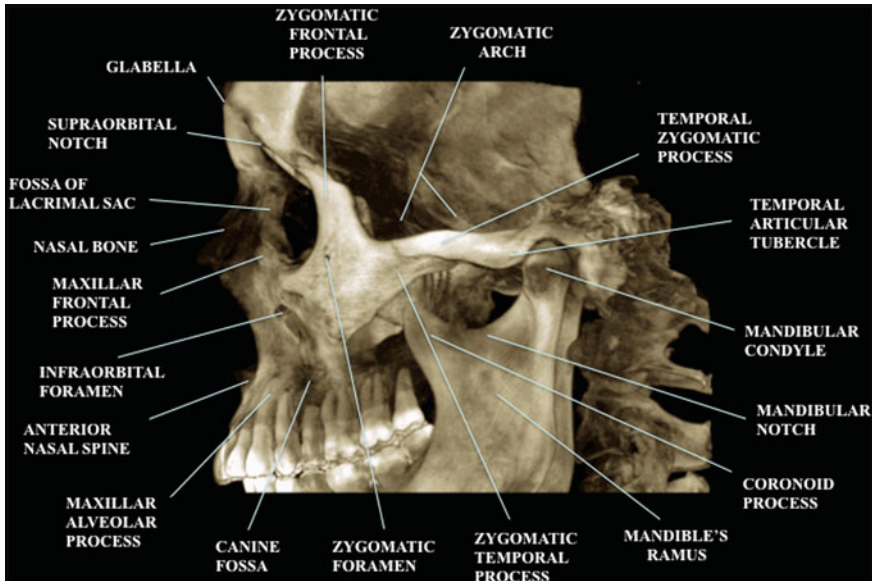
CBCT-3D reconstruction of the facial bones: lateral view
